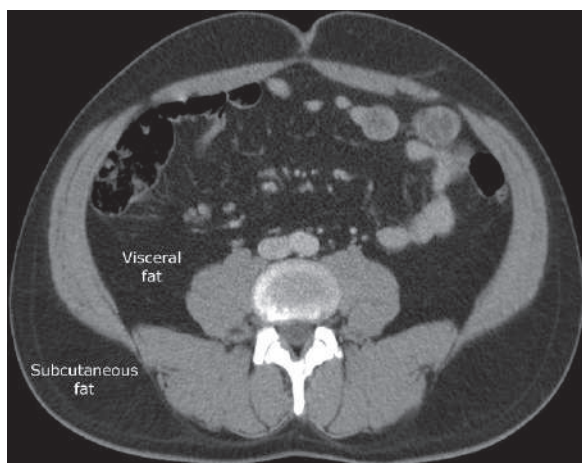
An axial CT section obtained at the level of L4/L5 vertebra
